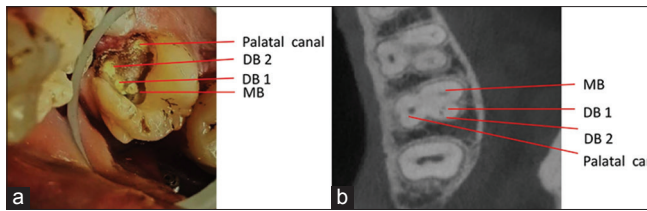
(a) Clinical view of canal location, (b) cone-beam computed tomography imaging showing two distobuccal canal in maxillary 2nd molar
